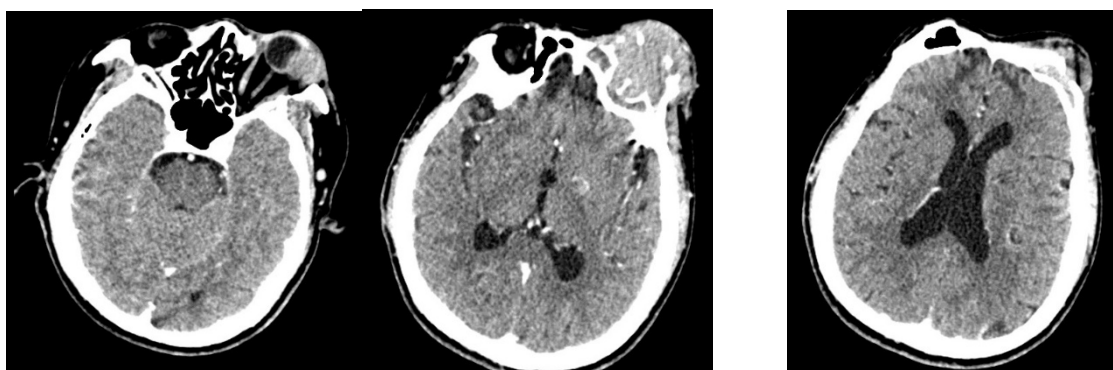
Contrast CT head shows left orbita tumor. Seen in the picture the left eye was protruded and N. II was intact
